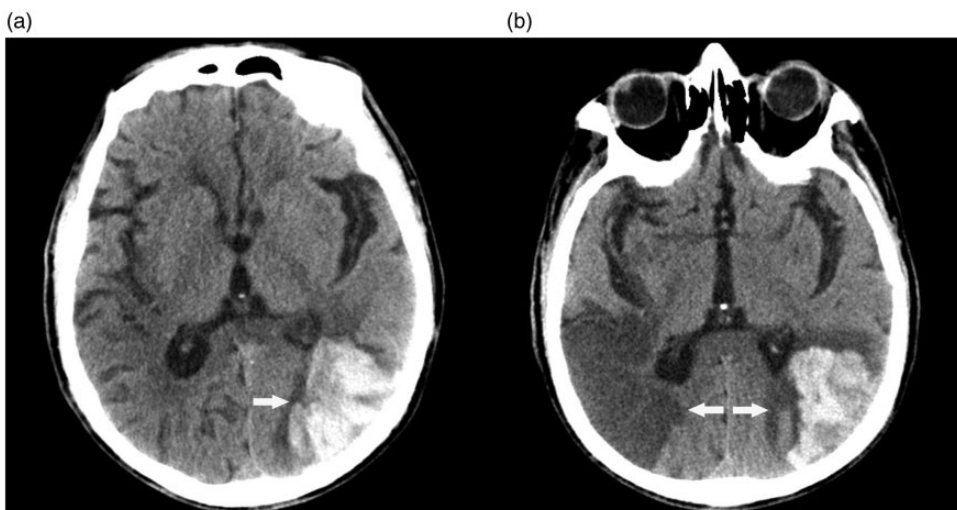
Brain computed tomography (CT) images. (a) Brain CT on admission showed hemorrhage (arrow) in the left temporal–occipital junction. (b) Brain CT reexamination the following day revealed infarcts (arrows) in the bilateral temporo-parieto-occipital junction with hemorrhagic transformation.
